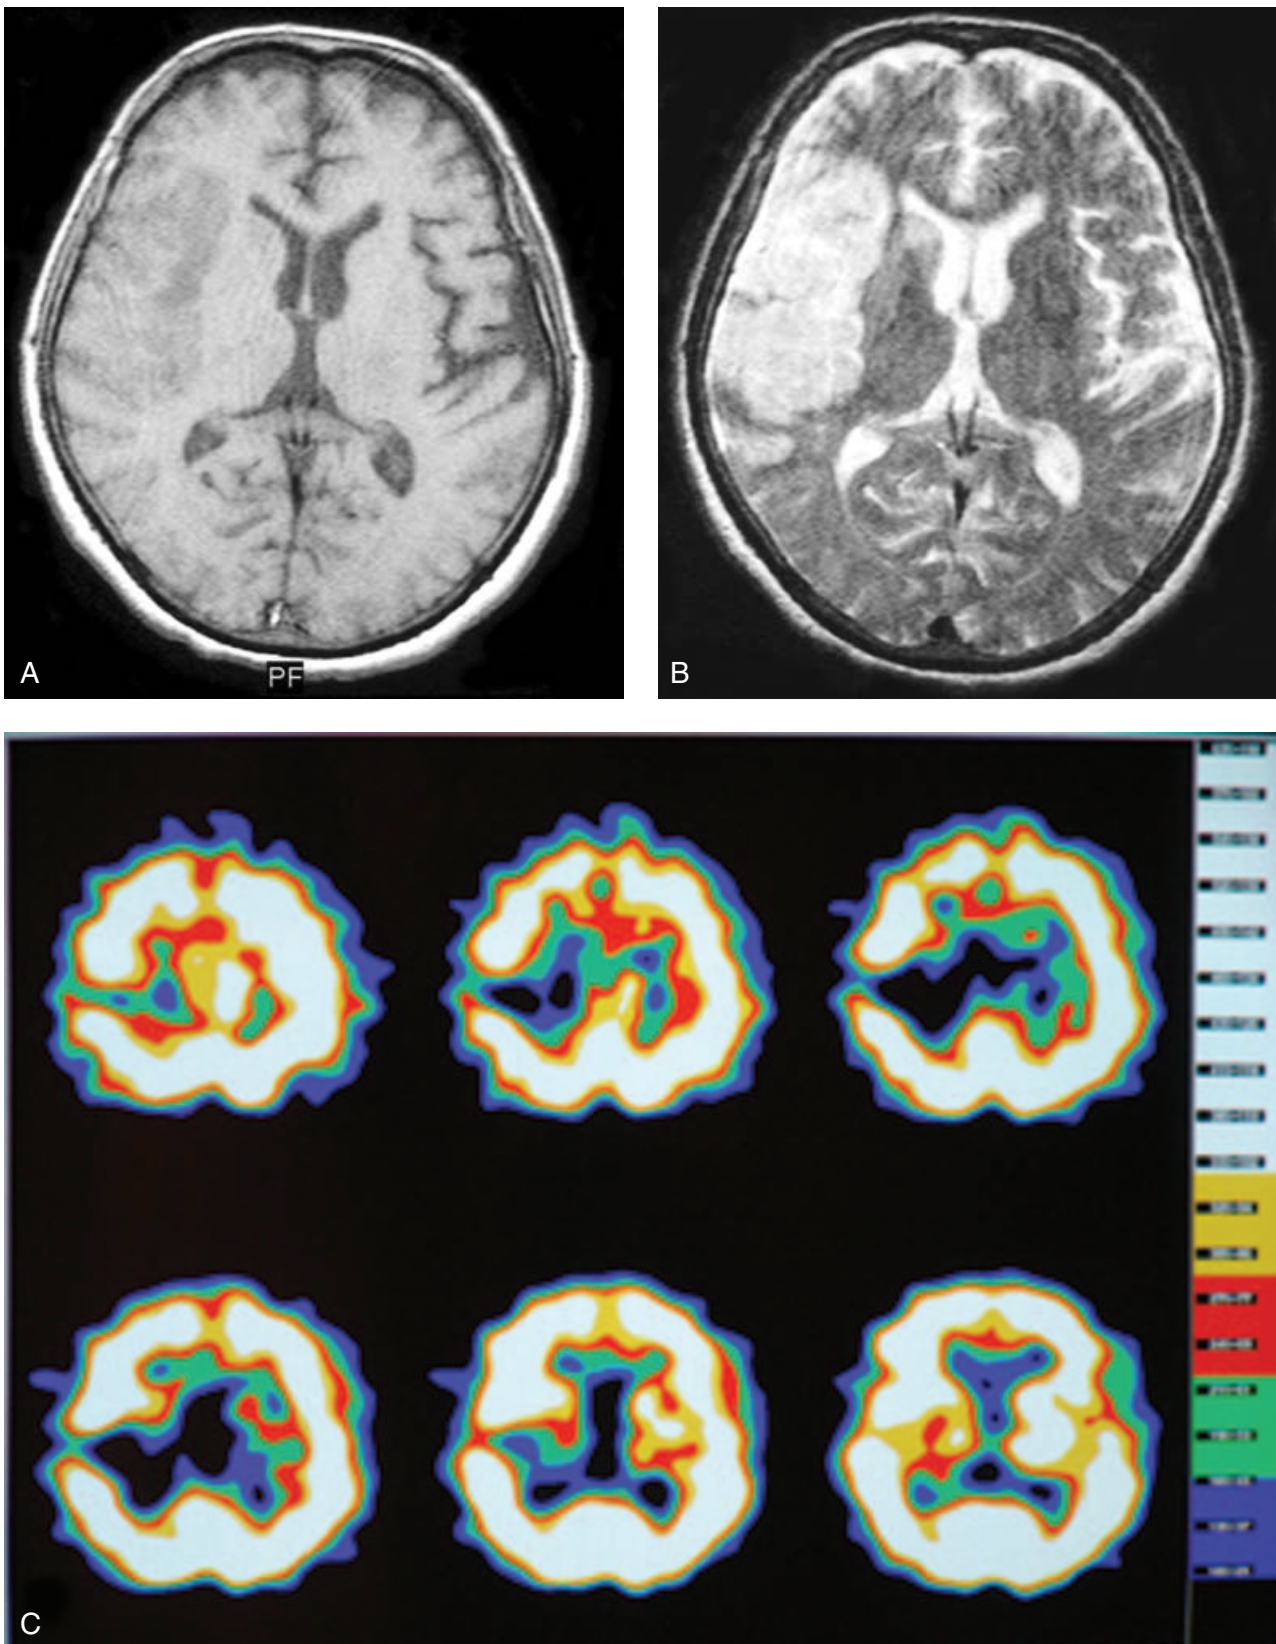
Severe perfusion defect. Axial T1-weighted (A) and T2-weighted (B) MR scans show the typical wedge-shaped infarct. Lesions can be seen clearly in both the T1 and T2-weighted images. C. Axial HMPAO brain SPECT images show a severe hypoperfusion in the parietal region of the right hemisphere.
